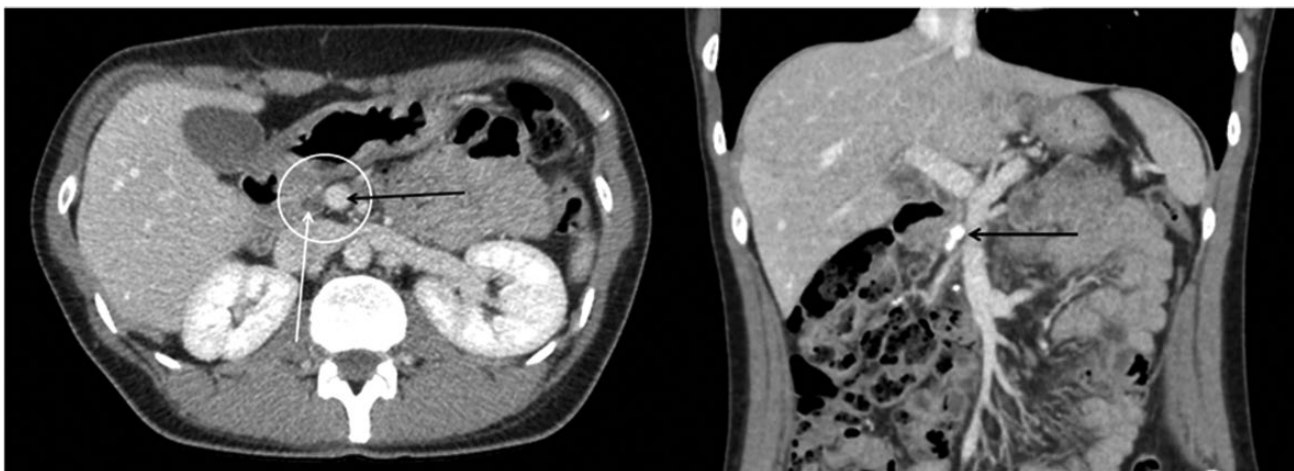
A 39-year-old female patient 9 years after a solitary episode of severe acute pancreatitis following hemorrhagic shock and acute respiratory distress syndrome (ARDS) due to atonic bleeding after cesarean section. This was followed by complete recovery and primary discharge from hospital after 5 weeks and complete remission of residual pseudocysts over a 6-month period. Afterwards, the patient had no clinical symptoms for 8 years before recurrent abdominal pain attacks irradiating to the back occurred. CT scan revealed nearly complete atrophy of the pancreatic parenchyma (left side, white circle; black arrow: portal vein, white arrow: bile duct) and a calcification in the pancreatic head (right side, black arrow). As no signs of inflammation, tumor suspicion, or endocrine insufficiency were present, symptomatic treatment was successful (oral enzyme replacement and analgesia).
